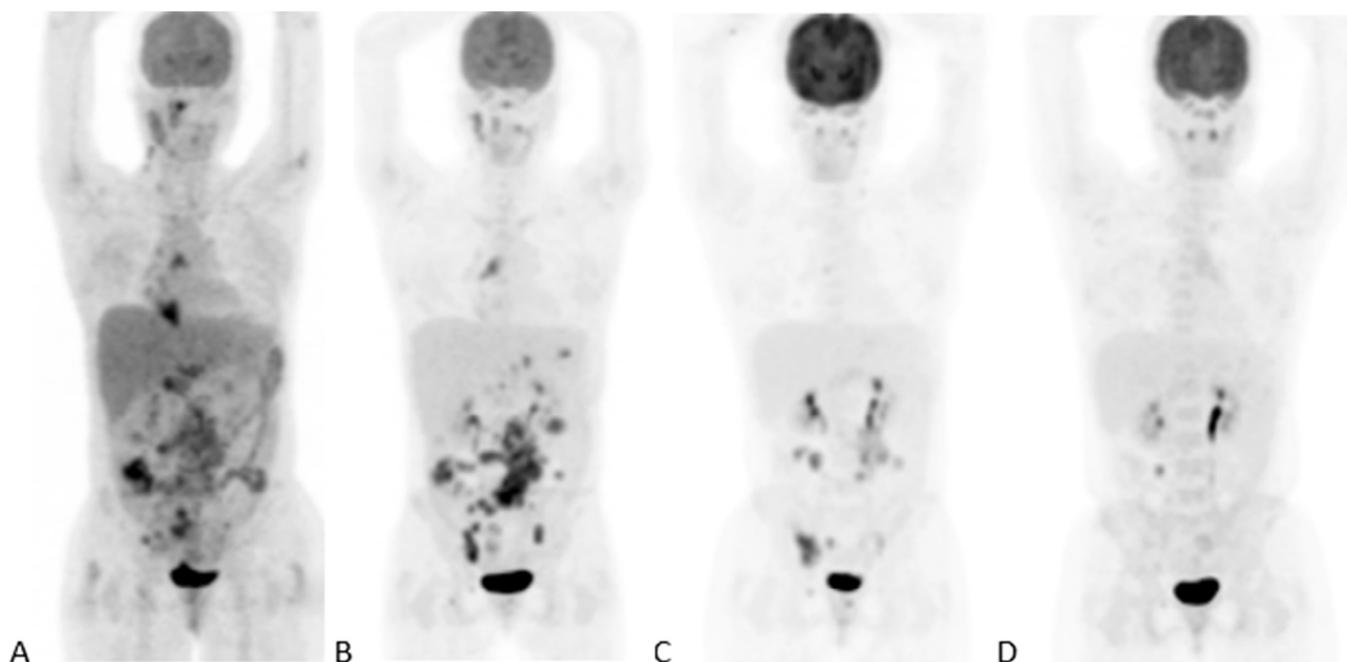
Maximum intensity projection ^{18}F -FDG-PET images in a 30-year-old woman with TB-HIV coinfection on TB therapy at baseline (A), 2 months (B), 6 months (C), and (D) 9 months. CD4 count was 86, and viral load was 122 copies per mL at baseline.
